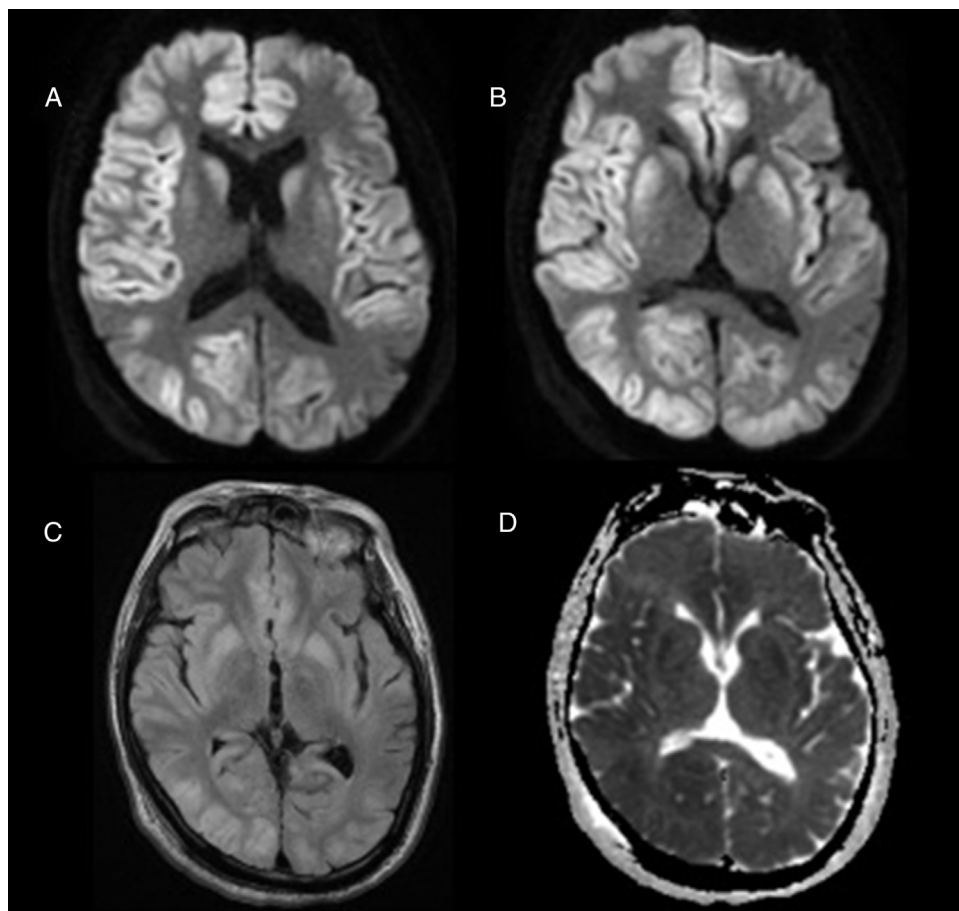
Brain MRI scan performed 48 hours after admission showing hyperintensities on the diffusion-weighted (A and B) and FLAIR sequences (C), with diffusion restriction on ADC maps (D).
